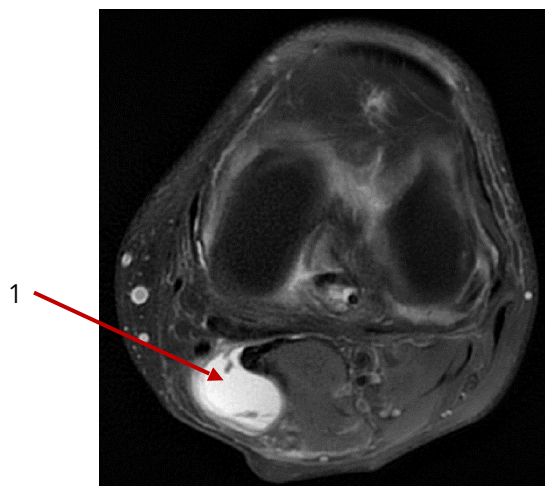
Magnetic resonance imaging (MRI): (1, 2) Baker's cyst
